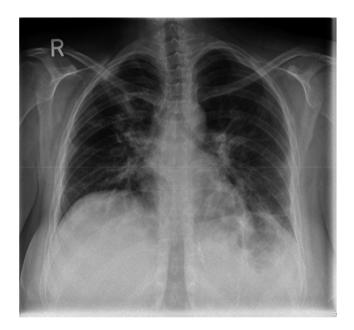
Chest X-ray of the patient while in MICU
